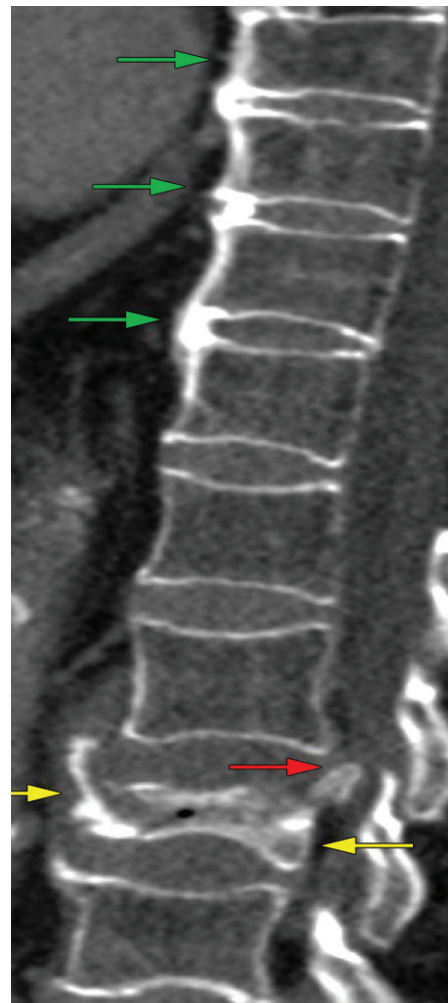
Rigid spine fracture in an 89-year-old man with DISH who fell back onto his bed and developed back pain. Sagittal CT image shows fused anterior flowing osteophytes (green arrows) in the lower thoracic spine, but the fracture was lower. An L3 burst compression fracture (yellow arrows) with retropulsion causing severe canal stenosis (red arrow) is depicted. Rigid spine fractures can occur just above or below the fused segment.
